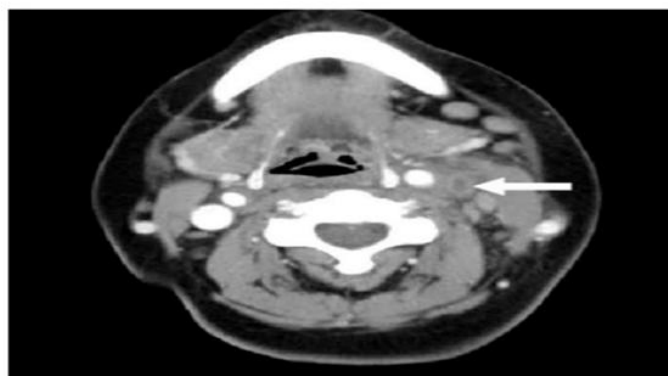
Axial neck contrast CT demonstrating filling defect in left Internal Jugular Vein
